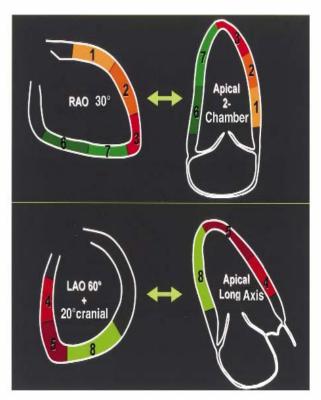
Correspondence between the myocardial segments analyzed on the biplane left ventricular angiogram (analysis of myocardial wall motion, left panels) and the two apical echocardiographic views (analysis of tissue Doppler imaging-derived preejection velocities, right panels): myocardial segments 1, 2, 3, 6, and 7 were analyzed on the right anterior oblique (IAO) projection and in the apical two-chamber view, respectively. Myocardial segments 4, 5, and 8 were analyzed in the left anterior oblique (IAO) projection plus 20° cranial inclination and the apical long-axis view, respectively. Myocardial segments 1, 2, 3, 4, and 5 were considered to belong to the perfusion territory of the left anterior descending coronary artery; myocardial segments 6, 7, and 8 were considered to belong to the perfusion territory of the dominant right coronary artery (15,16).
